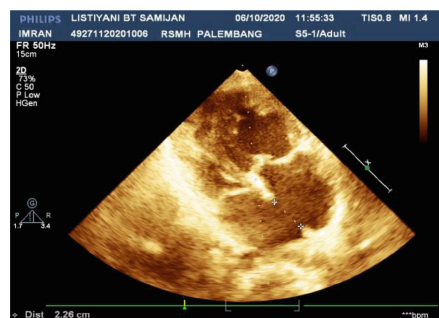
Echocardiography showed right ventricle dilatation, right atrial dilatation, atrial septal defect.
